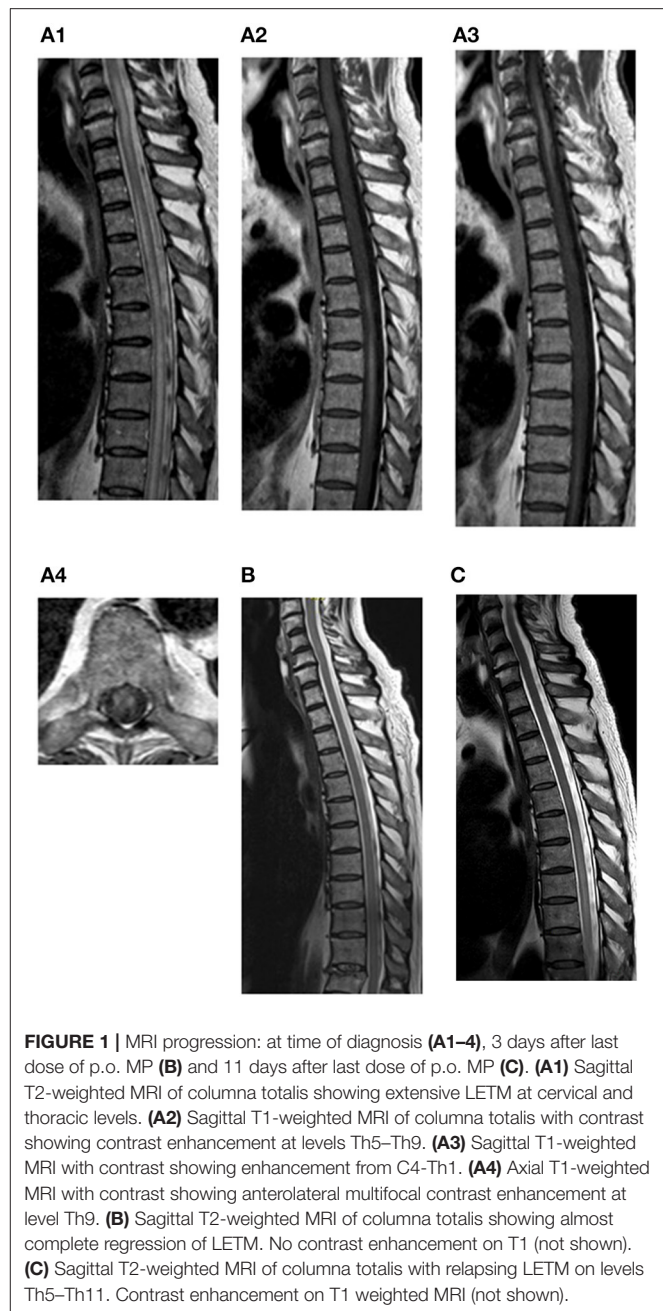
MRI progression: at time of diagnosis (A1–A4), 3 days after last dose of p.o. MP (B) and 11 days after last dose of p.o. MP (C). (A1) Sagittal T2-weighted MRI of columna totalis showing extensive LETM at cervical and thoracic levels. (A2) Sagittal T1-weighted MRI of columna totalis with contrast showing contrast enhancement at levels Th5–Th9. (A3) Sagittal T1-weighted MRI with contrast showing enhancement from C4–Th1. (A4) Axial T1-weighted MRI with contrast showing anterolateral multifocal contrast enhancement at level Th9. (B) Sagittal T2-weighted MRI of columna totalis showing almost complete regression of LETM. No contrast enhancement on T1 (not shown). (C) Sagittal T2-weighted MRI of columna totalis with relapsing LETM on levels Th5–Th11. Contrast enhancement on T1 weighted MRI (not shown).
